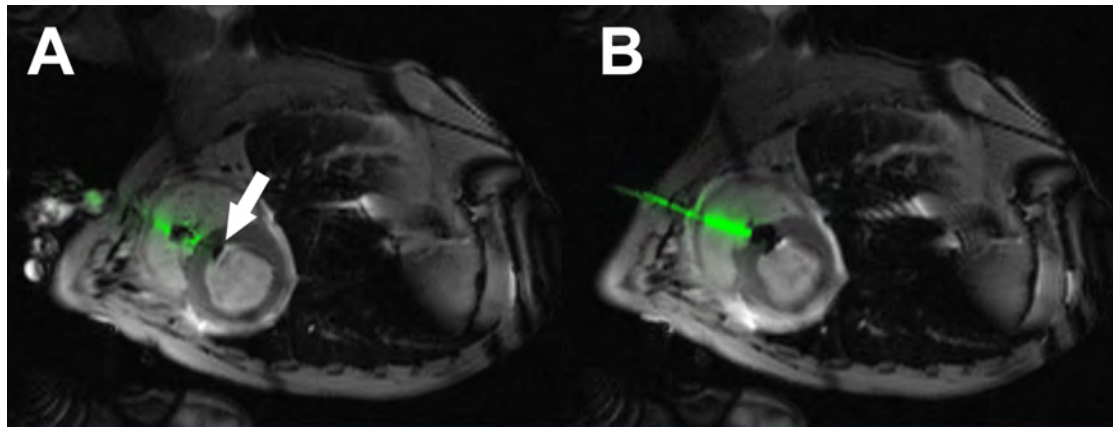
iCMR direct transthoracic ventricular septal defect closure
